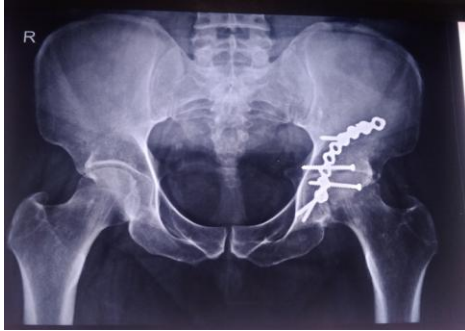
1 This is an x-ray of the pelvis, AP view, showing the posterior system. The acetabular bone was fixed with an exploration plate using the Kocher Lagenbeck approach.
